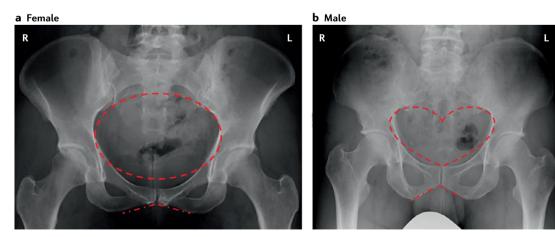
Anatomical differences in pelvic anatomy in men and women with axial spondyloarthritis. Radiographs of the anterior—posterior pelvis (frontal plane). \mathbf{a} | The pelvis in a woman with axial spondyloarthritis (axSpA) without radiographic damage (non-radiographic axSpA). \mathbf{b} | The pelvis in a man with axSpA with radiographic damage (ankylosing spondylitis). Dashed red lines indicate anatomical differences of the pelvis in women and men. 'L' and 'R' indicate the left-hand and right-hand sides of the patients, respectively.
